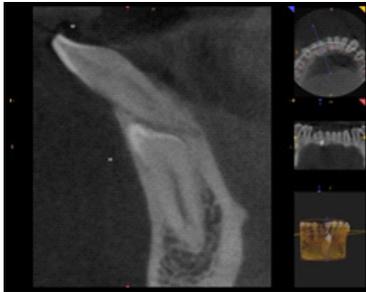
CBCT section demonstrating proximity of the crown of impacted tooth 43 to the root of tooth 42
